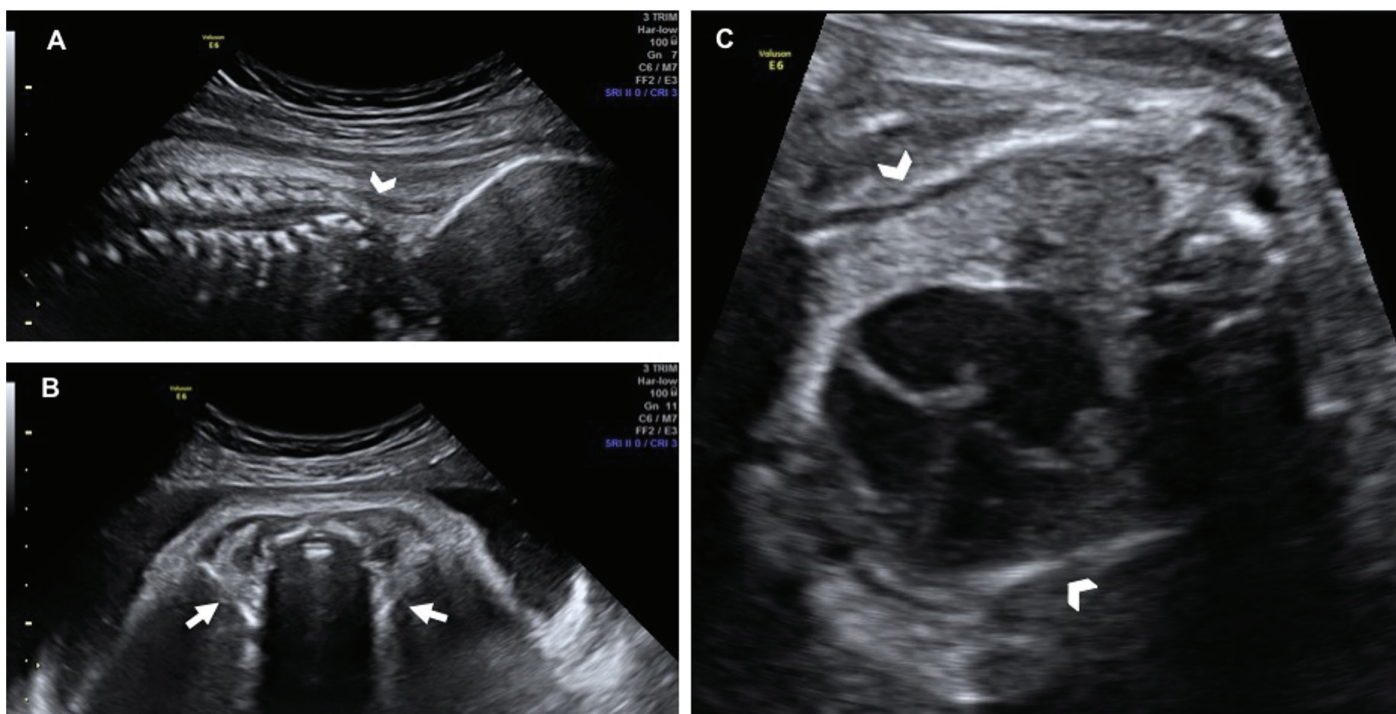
Two-dimensional (2D) ultrasound images of the fetus at 32 weeks of gestation showing abnormalities in fetal spine, clavicles and thorax. (A) Cervical spine misalignment (arrowhead). (B) Straight clavicles (arrow). (C) Thoracic narrowing (arrowhead)
